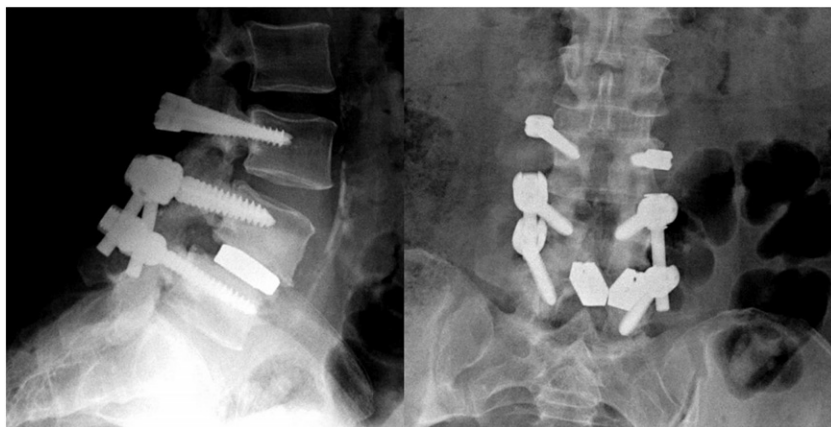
Lateral and anteroposterior radiographs 1 month following surgery, demonstrating development of left L3 screw halo sign.
